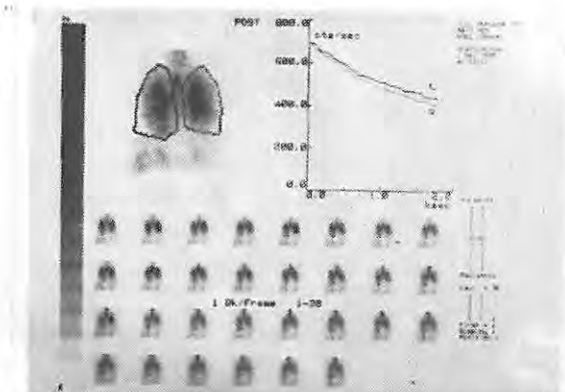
Technetium-99m DTPA aerosol scintigraphy of patient 11 (T1/2 right= 37.2 min, left= 36.5 min)
